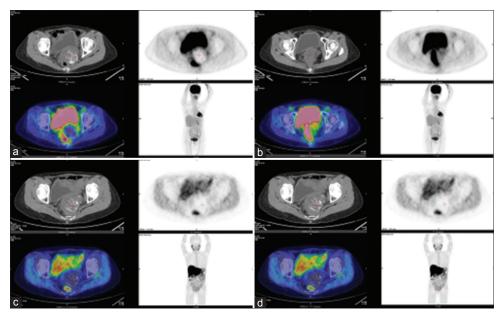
Whole-body positron emission tomography/computed tomography images of a 52-year-old woman with recurrent gestational trophoblastic neoplasia, posttotal hysterectomy with bilateral salpingo-oophorectomy. No hypermetabolic lesions were detectable at the residual calcified mass after chemotherapy in either [<sup>18</sup>F]-2'-fluoro-2'-deoxy-D-glucose positron emission tomography/computed tomography (a and b) or [<sup>18</sup>F]-fluorocholine positron emission tomography/computed tomography (c and d). Contrast material was not used due to severely impaired renal function
